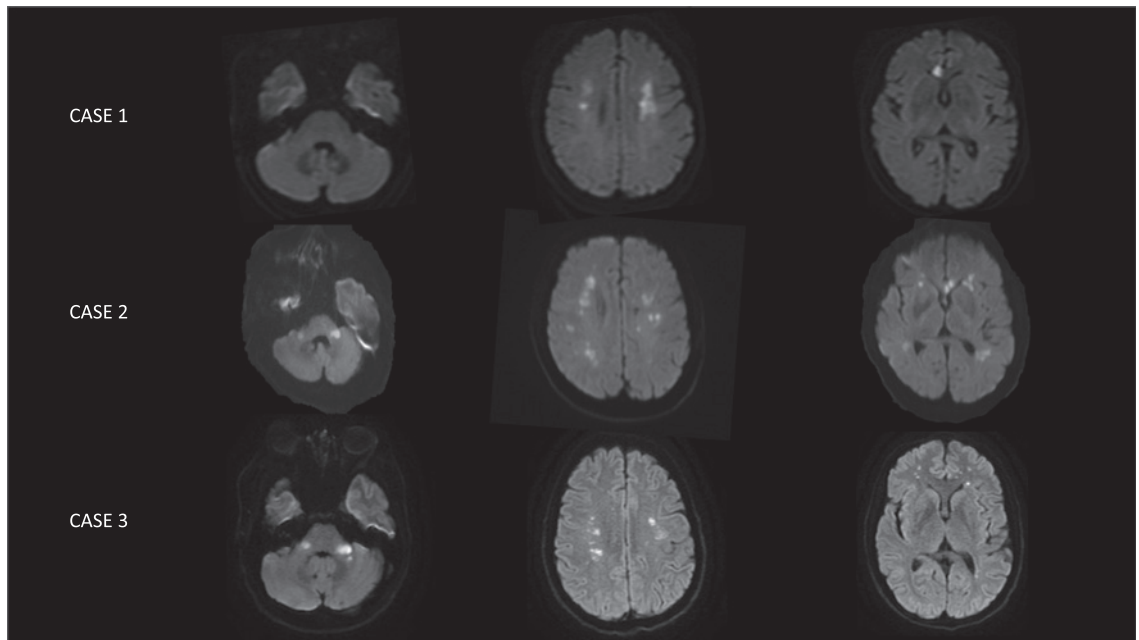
Acute ischemic lesions observed in the 3 CADASIL patients (diffusion-weighted magnetic resonance imaging). Acute ischemic lesions are observed in bilateral deep watershed regions of cerebral hemispheres (cases 1–3, middle column), in bilateral medium cerebellar peduncles (cases 2 and 3, left column), and in genu of corpus callosum (cases 1 and 2, right column).
